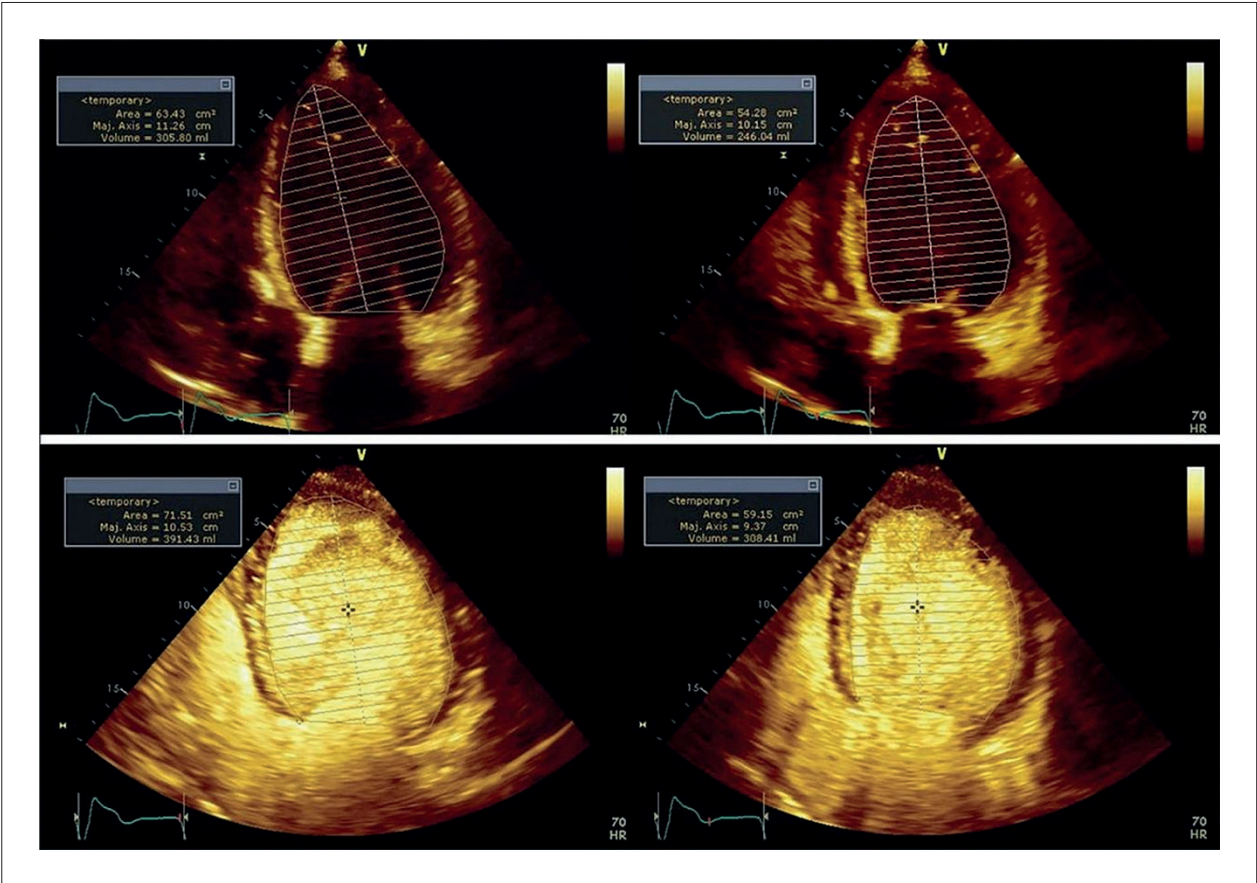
Differences in end-diastolic and end-systolic volumes observed in the same patient without contrast (top) and with UEAs and low MI imaging (bottom). Top row, left to right: Pre-contrast quantification of LV end-diastolic volume (306 mL) and end-systolic volume (246 mL) for LVEF estimation. Bottom row, left to right: Post-contrast quantification of LV end-diastolic volume (391 mL) and end-systolic volume (308 mL) for LVEF estimation. A marked increase in measured volumes is observed following contrast administration. LV: left ventricle; LVEF: LV ejection fraction; MI: myocardial infarction; UEA: ultrasound enhancing agent.
